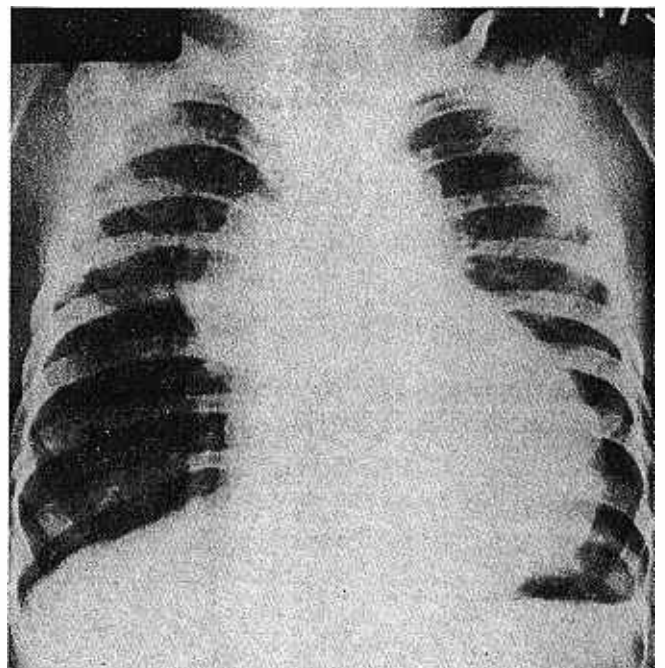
Chest radiograph of a 14-month-old child with tetralogy of Fallot and absent pulmonary valve demonstrating the aneurysmal dilatation of proximal right and left pulmonary arteries which is a feature of this condition.
